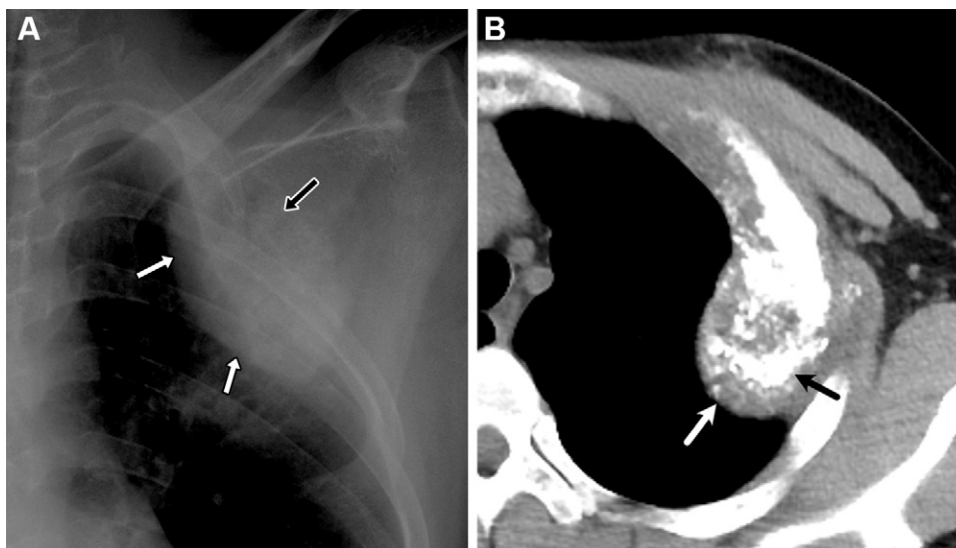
Osteosarcoma in a 17-year-old adolescent boy. (A) Frontal chest radiograph shows a large destructive lesion of the second rib with loss of cortical margins (white arrows) and dense cloudy internal attenuation (black arrow). (B) Axial CT image of the chest shows aggressive bone destruction (white arrow) with an extensive osteoid matrix (black arrow).
